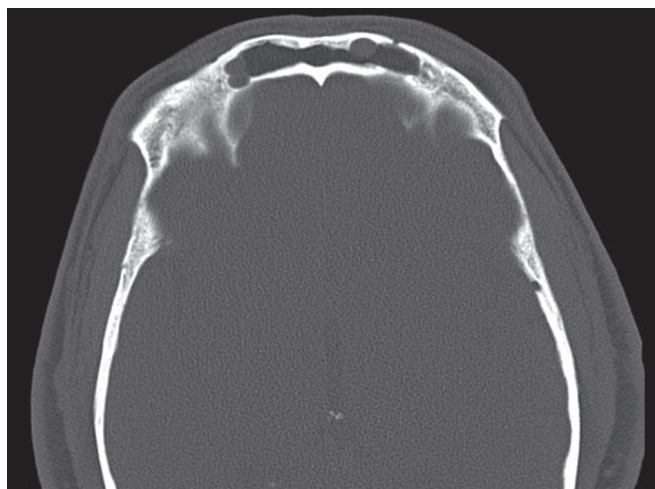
Axial CT demonstrating multiple mucocoeles along the periphery of the original dissection.
